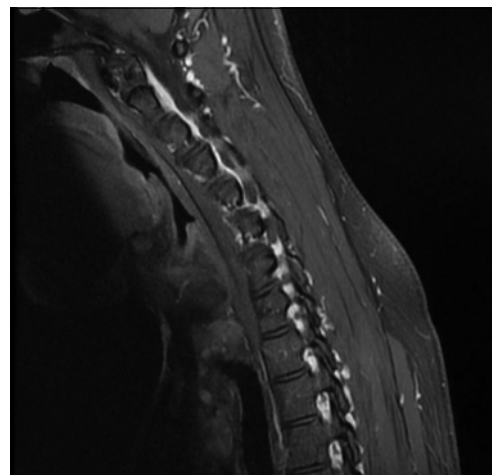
Sagittal flexion T2-weighted image shows anterior displacement of posterior dural sac and cord compression
